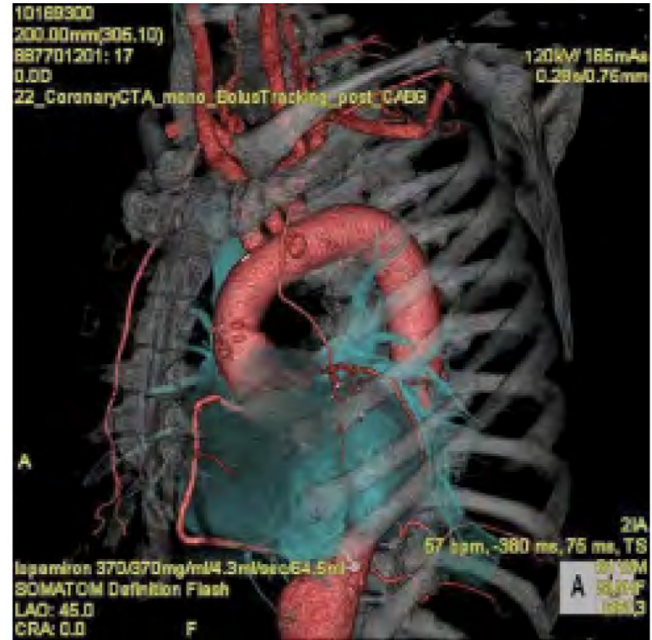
A postoperative computed tomography scan showing the Dacron graft and the left internal thoracic artery anastomosed to the left anterior descending artery.
